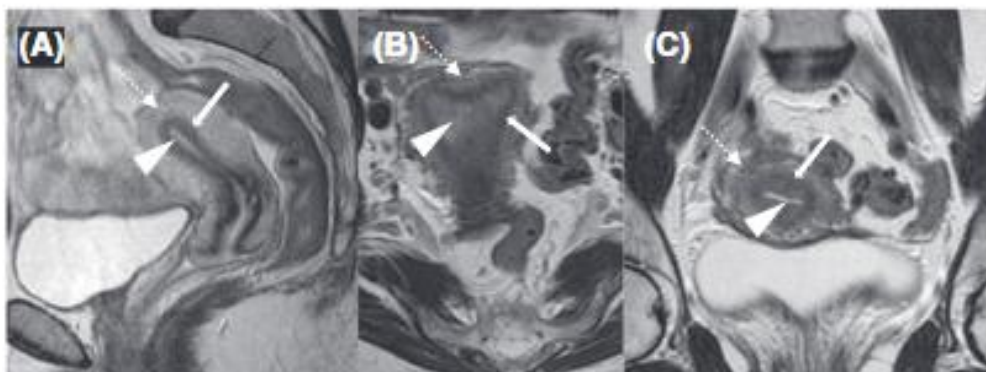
Normal zonal anatomy on T2- weighted MRI in (A) sagittal, (B) axial, and (C) coronal planes demonstrating high signal (bright) endometrium (arrowheads), low signal (darker) junctional zone or inner myometrium (solid white arrows), and intermediate signal (grey) outer myometrium.^[10]
